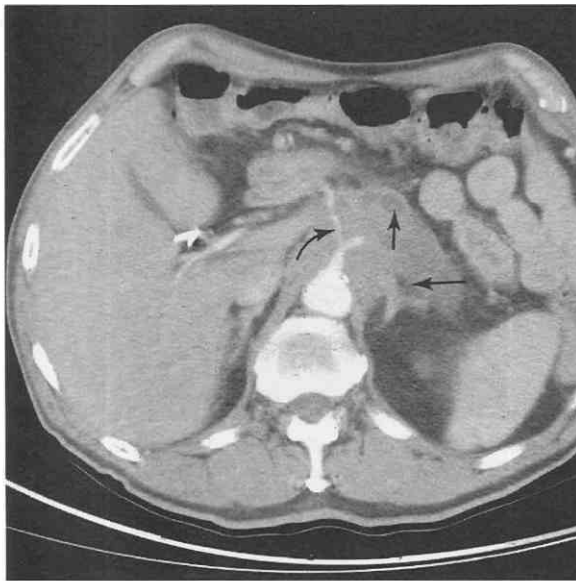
CT scan shows a large mass in the head of the pancreas that is encasing (*curved arrow*) the hepatic artery, originating from the celiac artery. Dilatation of the pancreatic duct is so severe that it is producing a retention cyst (*vertical arrow*). Left adrenal gland (*horizontal arrow*) is partially invaded on the medial surface.
